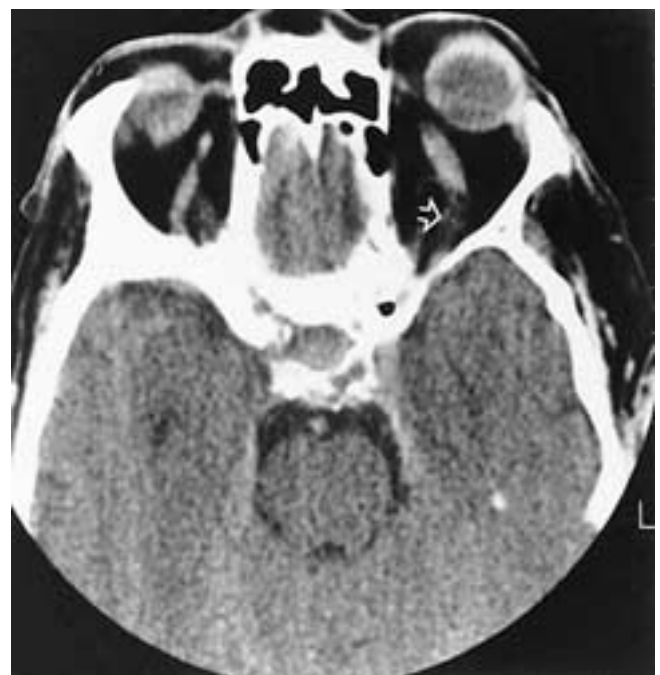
Thrombosis of the superior ophthalmic vein. Axial CT scan shows an engorged left superior ophthalmic vein with a filling defect (arrow), which was caused by a sphenoid sinus infection (moniliasis).
